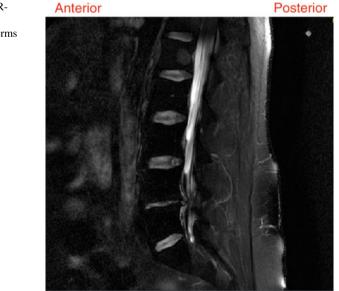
Sagittal T2-SPIRweighted MRI showing anterior and posterior terms [5]
